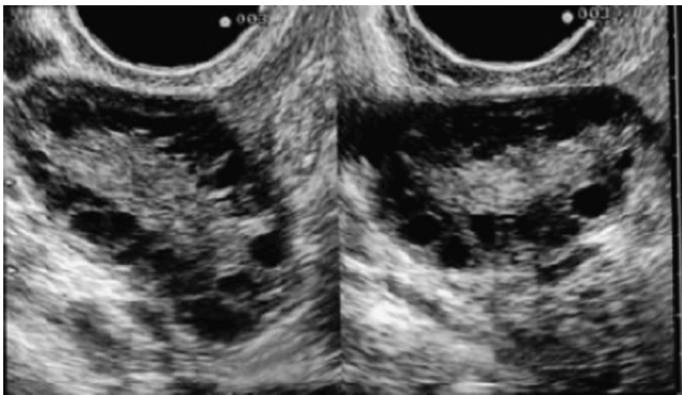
Sonographic depiction of bilateral polycystic ovaries: 10 or more follicles with peripheral distribution. (From Balen AH, Laven JS, Tan SL, et al. Ultrasound assessment of the polycystic ovary: international consensus definitions. *Hum Reprod Update* 2003;9:505–14; with permission.)
